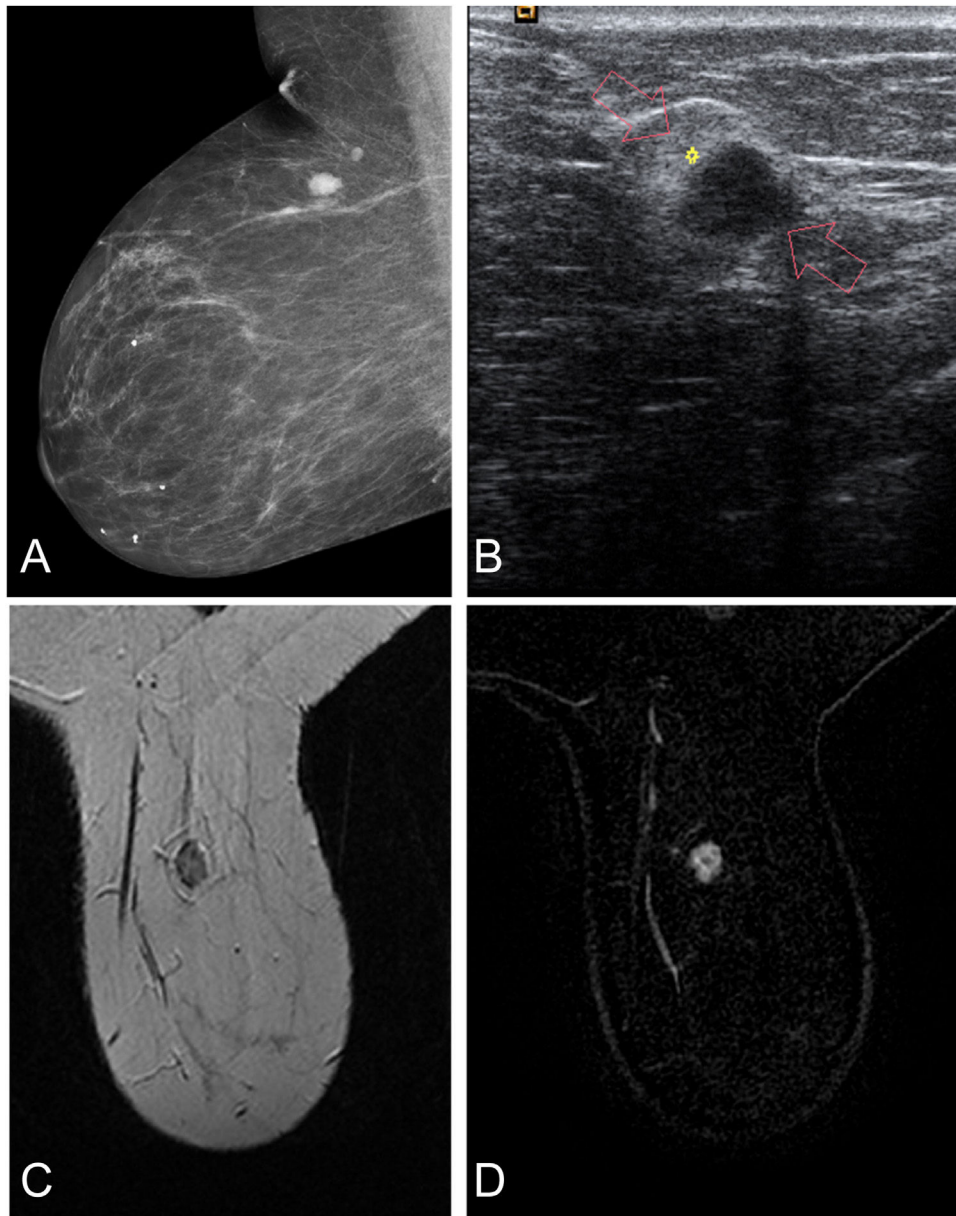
(A) Mammogram (MLO projection) shows a dense, oval mass with microlobulated margins at the junction of the upper quadrants of the right breast. (B) Echography image shows a parallel, oval, heterogeneous nodule with a hypoechoic centre and a peripheral hyperechoic border (*). (C) Axial T2-weighted image shows a well-defined mass with a predominantly hypointense heterogeneous centre. (D) Dynamic T1-weighted axial subtraction image shows heterogeneous enhancement of the lesion.
